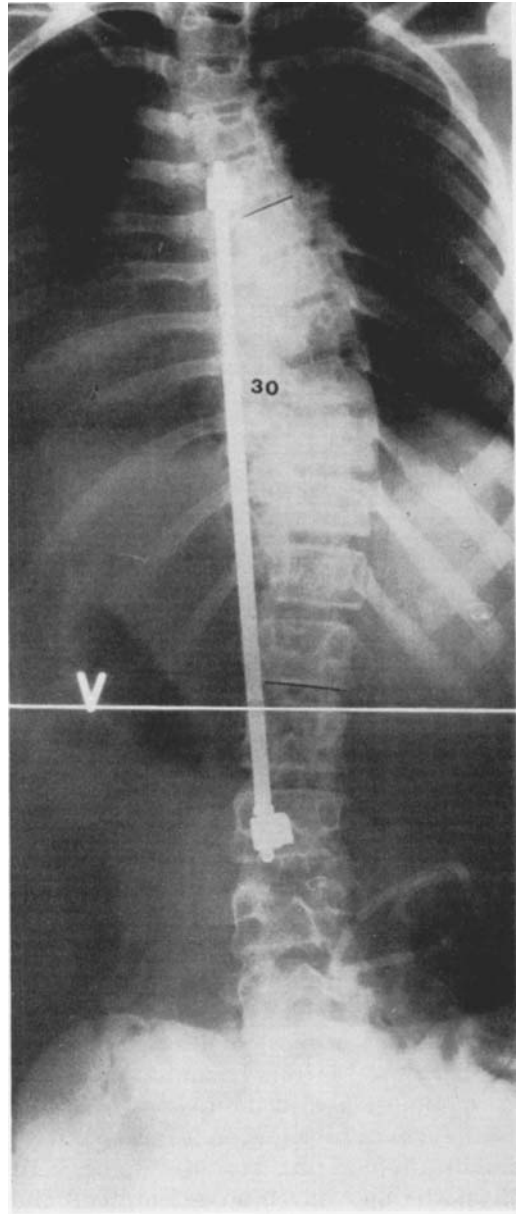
b. Supine roentgenogram made at the end of the operation shows correction to 30°.
